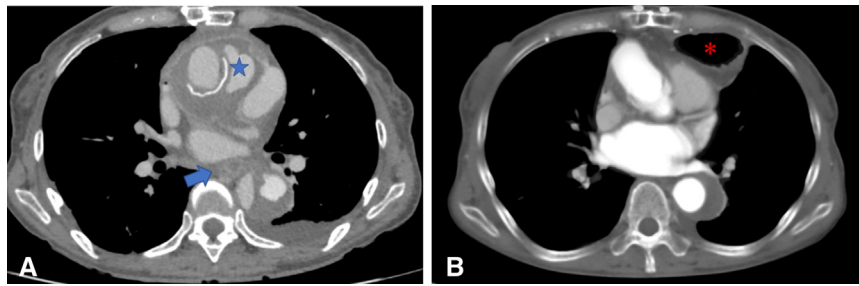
A, Preoperative computed tomography showing apseudoaneurysm at the proximal anastomosis (*blue star*) and an esophageal abscess (*blue arrow*). B, Postoperative computed tomography scan showing the primary gastric conduit (*red asterisk*).
